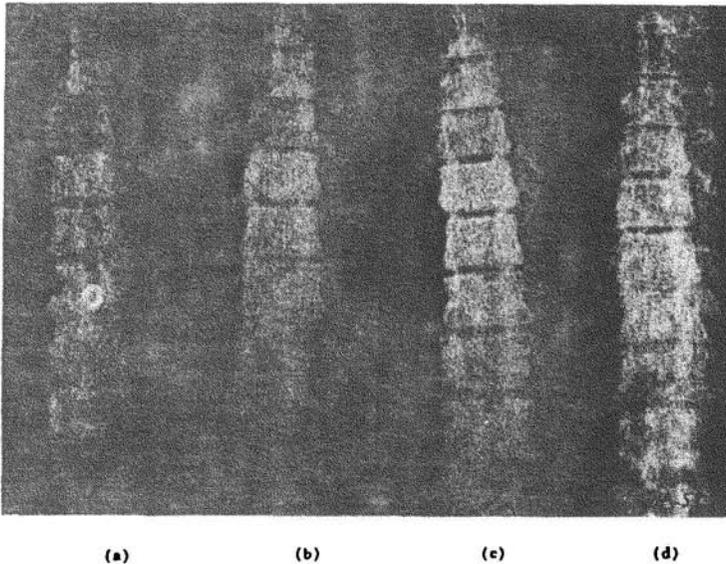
Radiographic evaluation of lumbodorsal spine (B.H.) in metastatic carcinoma of prostate.
